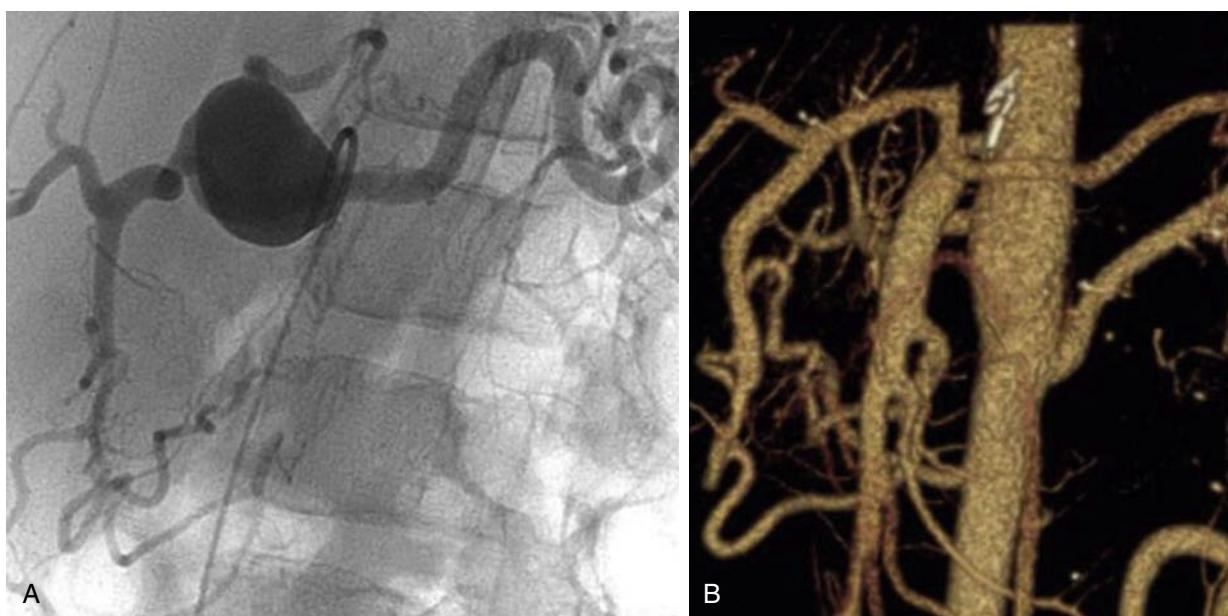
Celiac Artery Aneurysm. (A) Preoperative angiogram of a post-stenotic celiac artery aneurysm in a 13-year-old. (B) Postoperative computed tomographic arteriography image following resection of the aneurysm and primary end-to-end anastomosis of the proximal hepatic to proximal splenic artery. (From Davis FM, Eliason JL, Ganesh SK, Blatt NB, Stanley JC, Coleman DM. Pediatric nonaortic arterial aneurysms. *J Vasc Surg*. 2016;63:466–476.)
